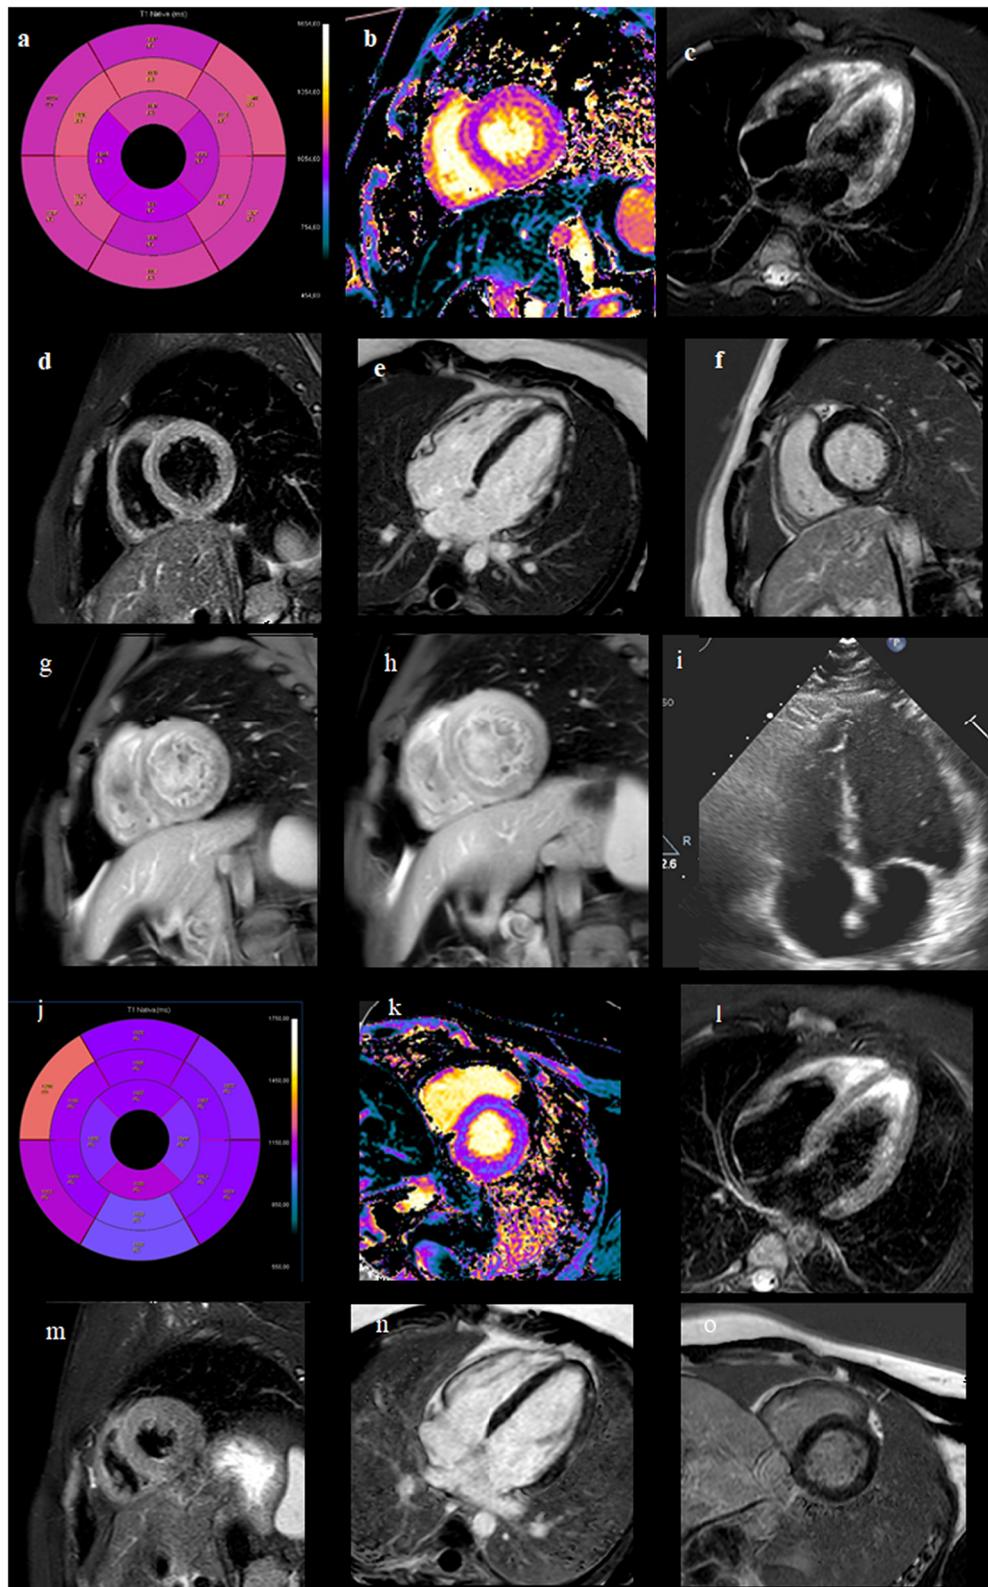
Serial imaging assessment a–b). Diffuse MRI signal increase of the left ventricular walls in the sequence T1 Native for the Mapping study. c–d) Signal increase with “patchy” distribution within left ventricular walls in the T2-STIR sequences for edema. e–f) Signal increase with “patchy” distribution within left ventricular walls in the PSIR sequence for Late Gadolinium Enhancement study compatible with myocardial necrosis in acute myocarditis. g–h) Multiple areas of increased signal with mid- and subepicardial distribution within left ventricular walls in the sequences for Early Gadolinium Enhancement. i) normal basal 2-dimensional echocardiogram. j–k) Two-month follow-up: Reduction of signal in the sequence T1 Native for the Mapping study. l–m) Absence of edema within left ventricular walls in the T2-STIR sequences. n–o) Remodeling and reduction of Late Gadolinium Enhancement areas compatible with fibrosis.
